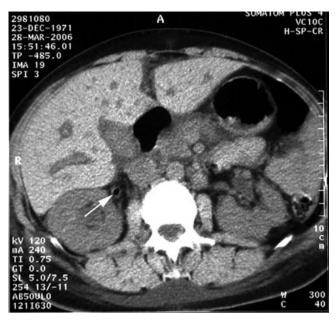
Emphysematous pyelonephritis: computed tomography tomography (CT) scan demonstrating gas in the right ureter (indicated by arrow) and a moderate hydronephrosis in a 34-year-old woman with type 1 diabetes. The responsible was organism was *E. coli*. She responded to antibiotics and drainage by nephrostomy, followed by ureteroscopy during which obstructing necrotic slough was removed. From Clark T, Abdalkareem M, Ali K. A case of emphysematous pyelonephritis. *J R Soc Med* 2009; 102:75–77, with permission.
